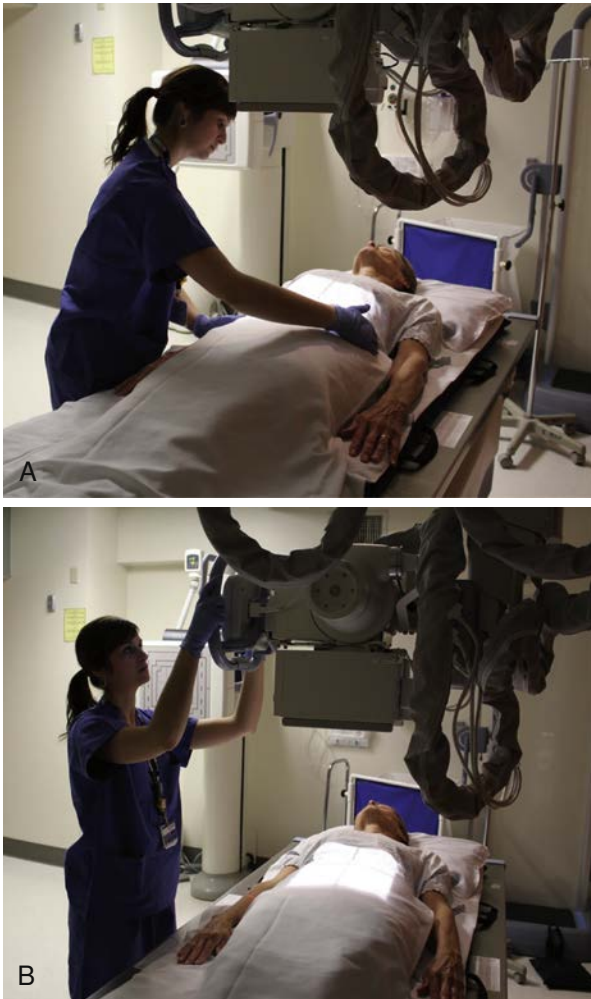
A, A radiographer aligns patient anatomy to an image receptor in a bucky tray. B, A radiographer aligns an x-ray tube to the patient and image receptor.
